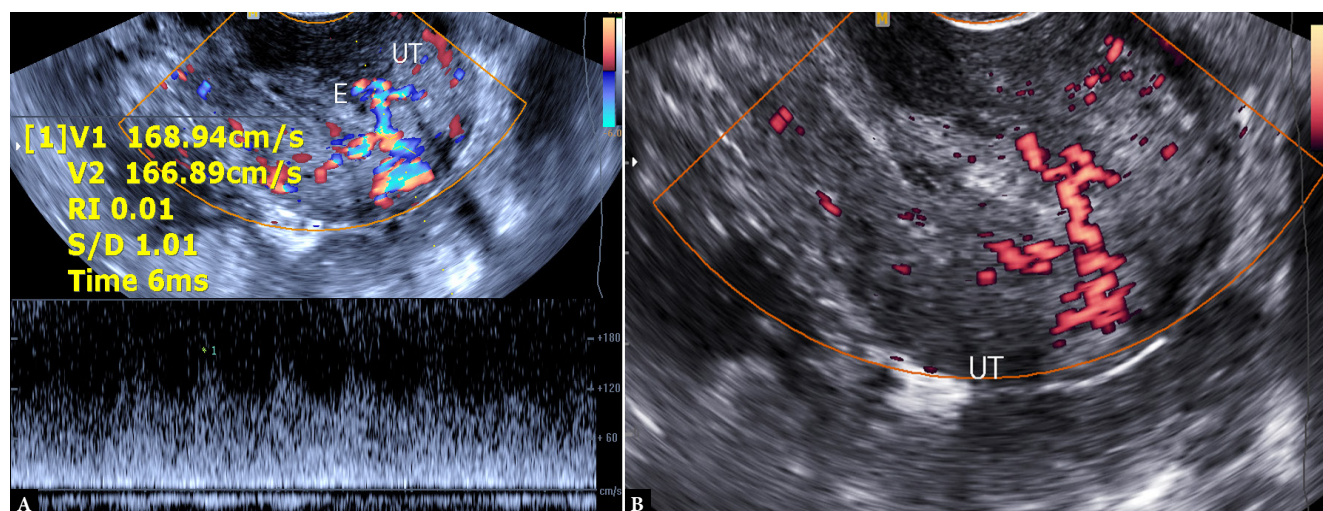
Transvaginal color duplex (CD) sonography examination showing enhanced myometrial vascularity, pattern type 11 with hypervascularity of the retained parts equal to that of the myometrium hypervascularity and low resistant arterial flow pattern
